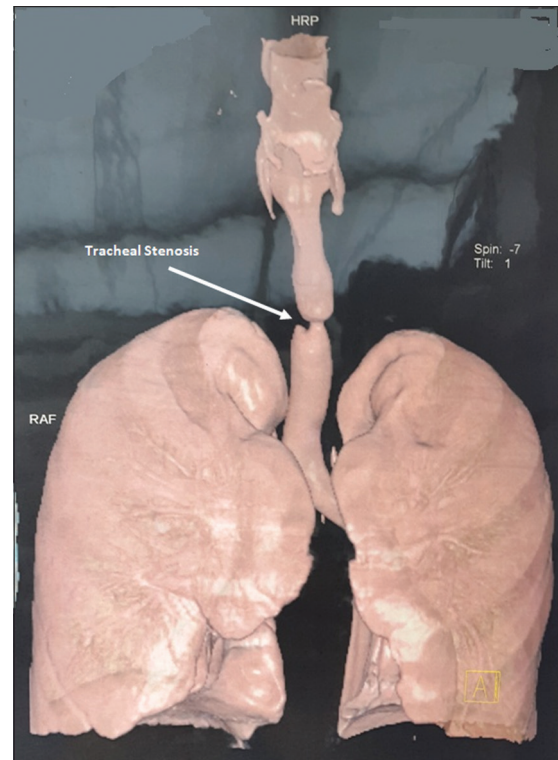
High resolution of CT of neck and thorax with three-dimensional reconstruction
